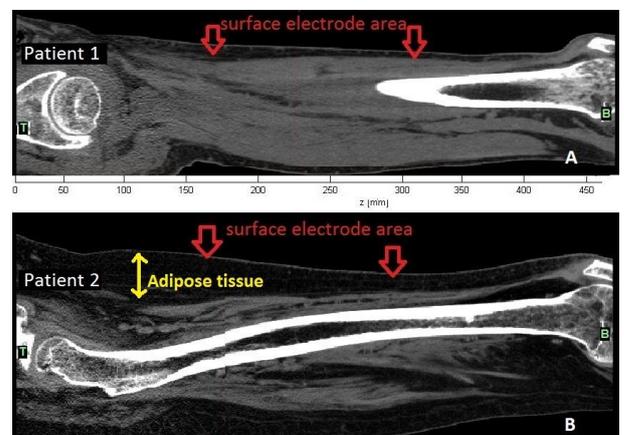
Spiral CT pictures sagittal view at beginning of the FES treatment: patient 1 (A), patient 2 (B).
